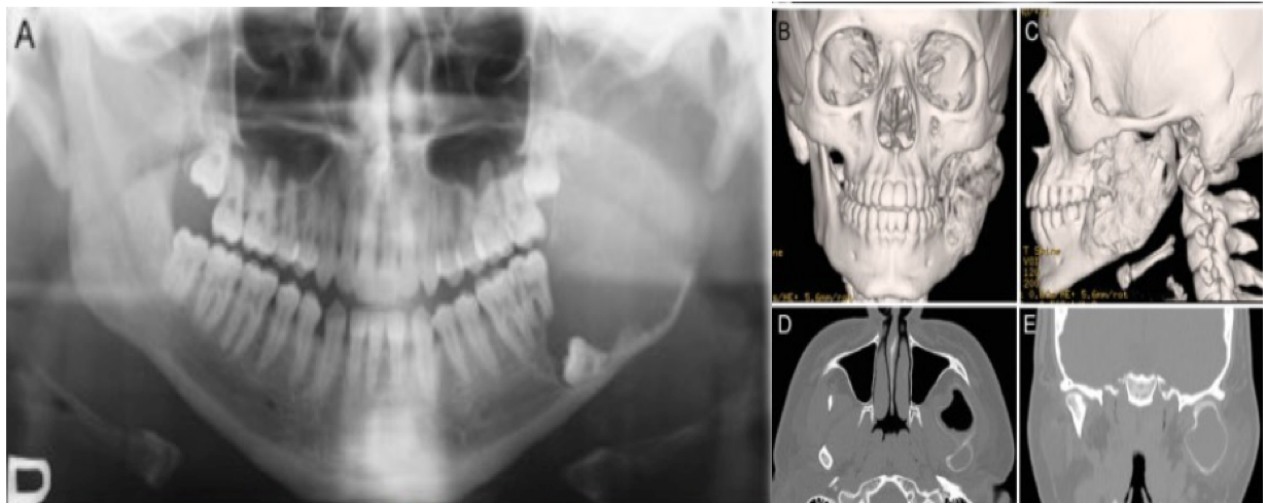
Unicyclic Ameloblastoma; A. Unicyclic panoramic view of ameloblastoma on left mandibular ramus and condyle; B and C. 3D CT scan picture of unicyclic ameloblastoma in left mandibular ramus and condyle involving buccal, lingual, anterior and posterior expansion; D. Coronal CT image of invasion of the condylar head and condylar expansion¹²
